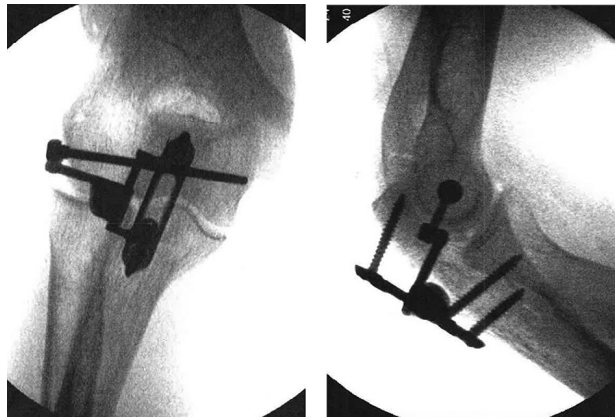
Intraoperative anteroposterior and lateral radiograph of the patient after stabilization surgery with the internal joint stabilizer of the elbow.
